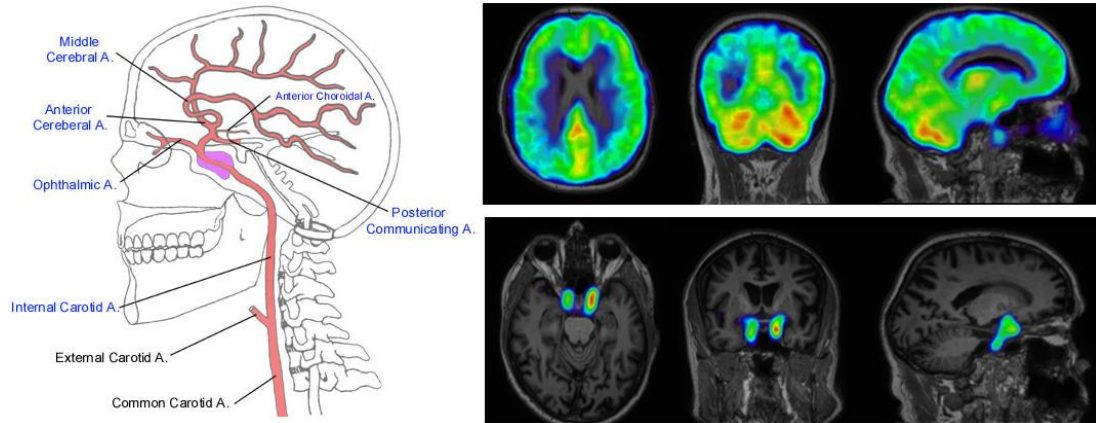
Map of Arteries. 1st and 2nd principal component co-registered with the MRI scan.
